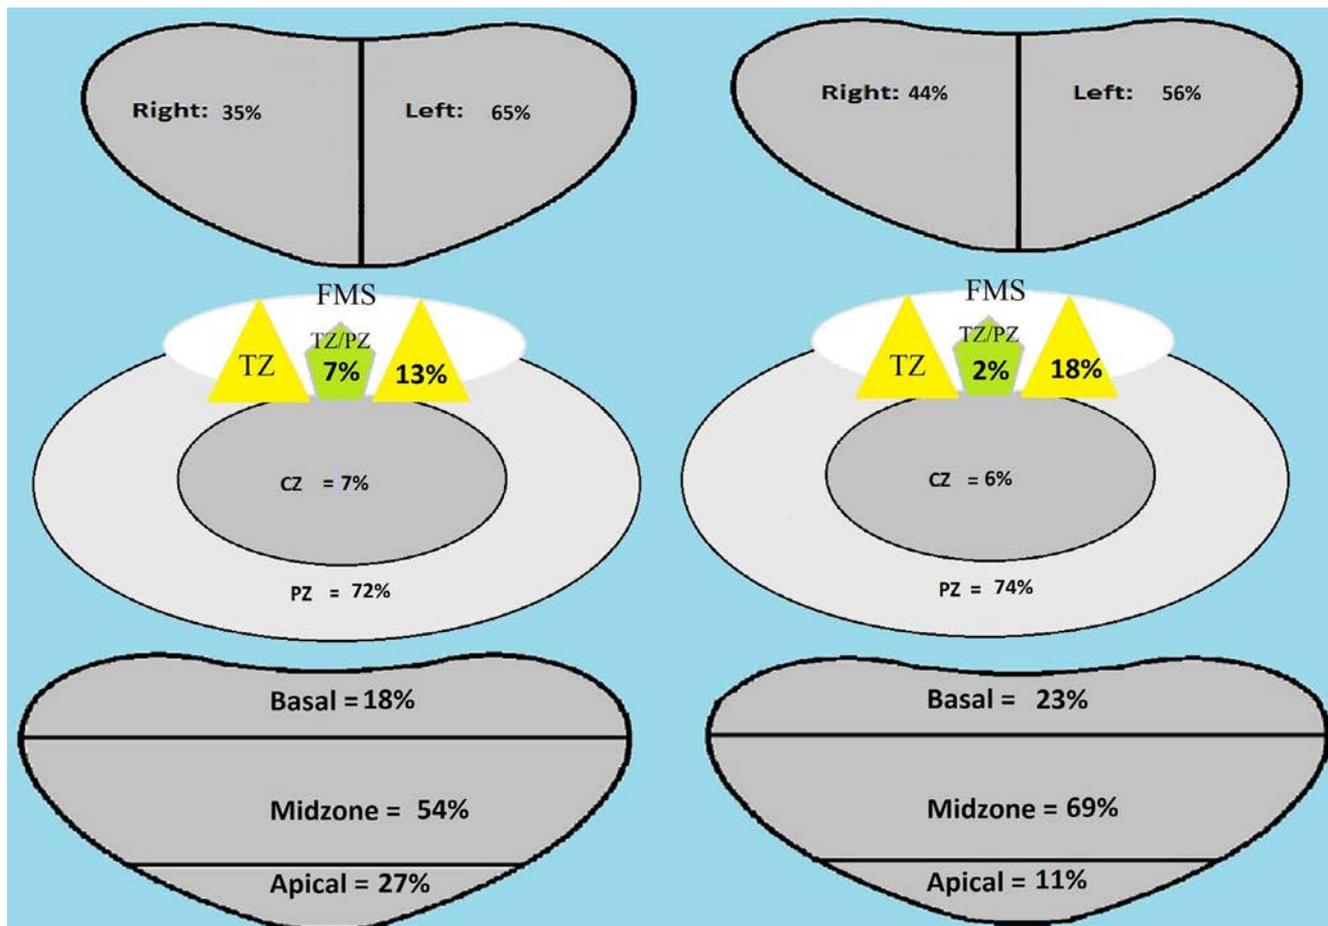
Distribution of the regions of interest seen on magnetic resonance imaging of the prostate in African American (left) and Caucasian patients (right) treated at Henry Ford Health System in Detroit.
